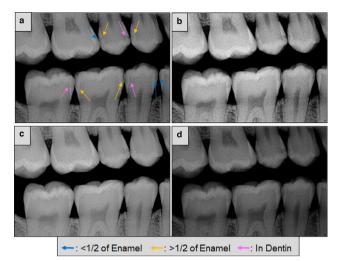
Sample images of intraoral bitewing radiograph in this investigation with different contrast and lightness. (A) arrows indicate caries lesion determined by the consensus of two HSDM full-time faculty: Gold-standard. (B) Image with a higher contrast and lightness than A. (C) Image with same contrast and higher lightness. (D) Image with a higher contrast and darker lightness.
